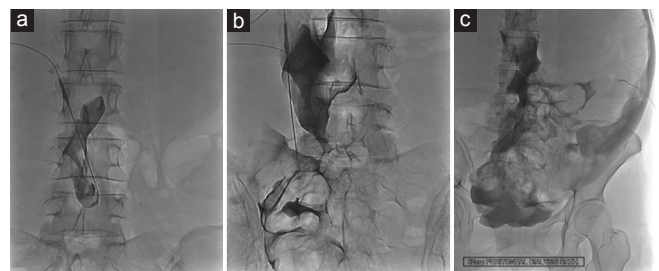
A 50-year-old woman with known end-stage renal disease on long-term peritoneal dialysis through a surgically placed catheter, which was removed due to peritonitis. (a) Initial access during percutaneous re-insertion of peritoneal dialysis catheter showing loculated contrast accumulation. (b) Another access demonstrating free spillage of contrast outlining the bowel. (c) Pelvic radiograph showing free contrast in the pelvis and left paracolic gutter
